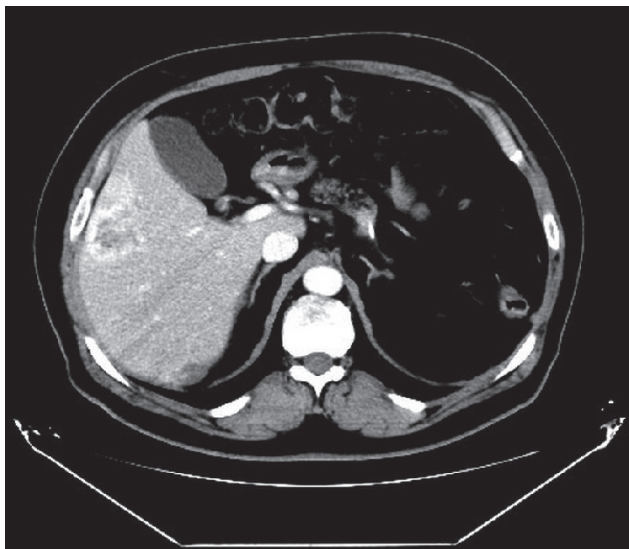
CT scan showing a single liver metastasis (type I) in segment V-VI from pancreatic NET
